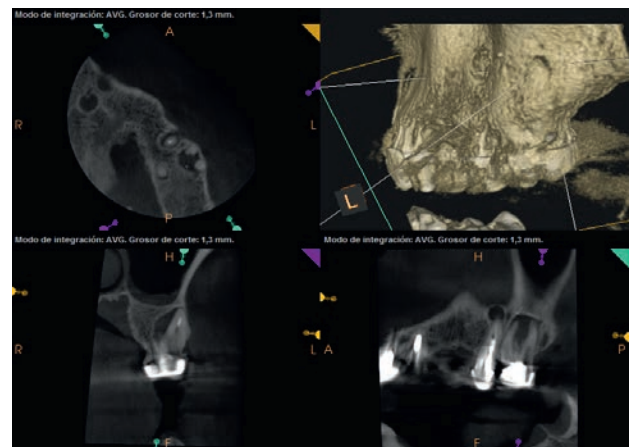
Upper left first molar preoperative CBCT image. Note subotturation at mesiobuccal and distobuccal canals.
